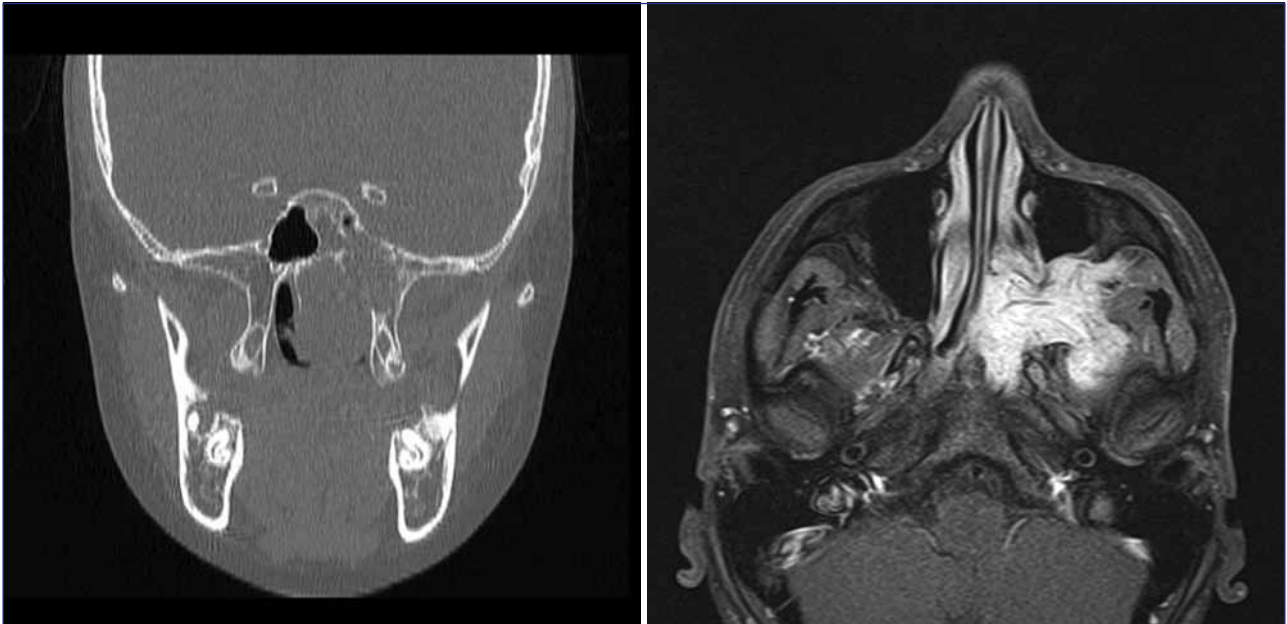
Left – CT showing a mass filling the nasopharynx, typical of JNA. Right – MRI shows widening of the sphenopalatine foramen and large tumour mass.*
